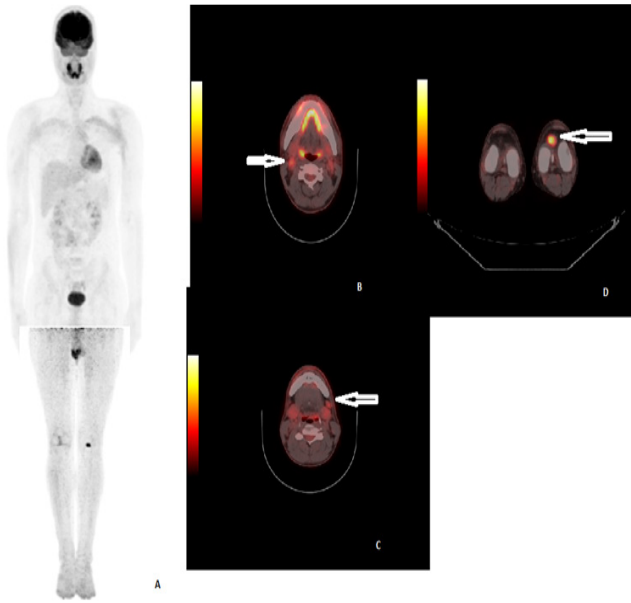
18 FDG PET/CT after 6 cycles of ABVD treatment A) MIP images, B-C) multiple lymph node involvement, D) splenic lesion, E) focal patellar uptake (white arrows).
